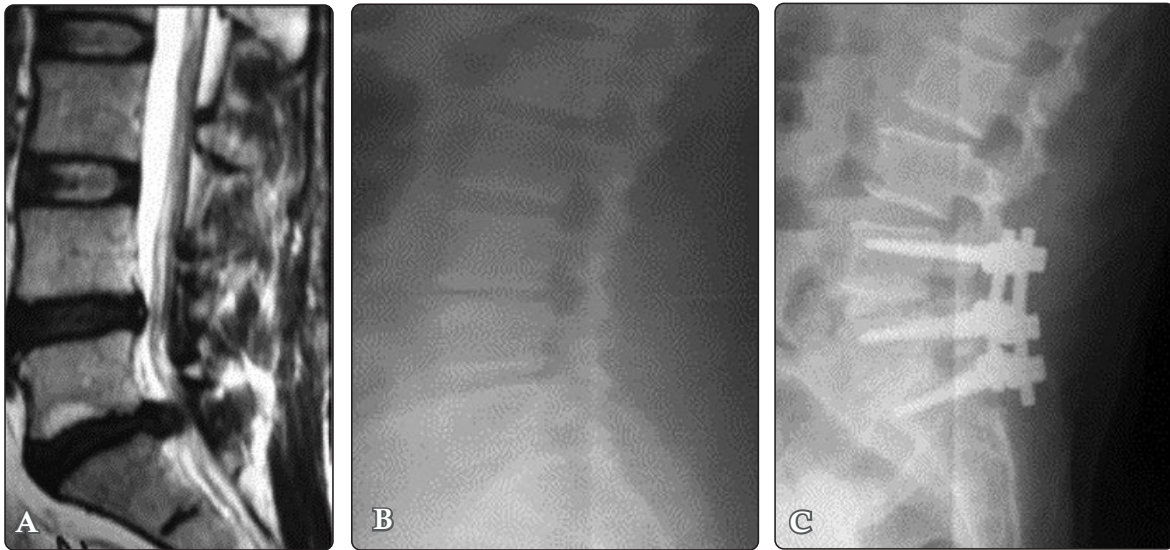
(A) T2WI sagittal MRI of a 57-year-old male patient showing degenerative changes in both L4/L5 and L5/S1 discs together with posterolateral L5-S1 disc herniation. ODI= 56; VAS= 8; smoking: yes; vitamin D status: low. (B) Lateral radiograph showing the L4/L5 and L5/S1 degenerative changes. (C) Six-month postoperative plain radiograph only local bone graft was used for both levels. Bone graft is seen bridging the disc space with lucency noted below the bone graft, indicating incomplete fusion (Bridwell's grade 3). ODI=24; VAS=3.
